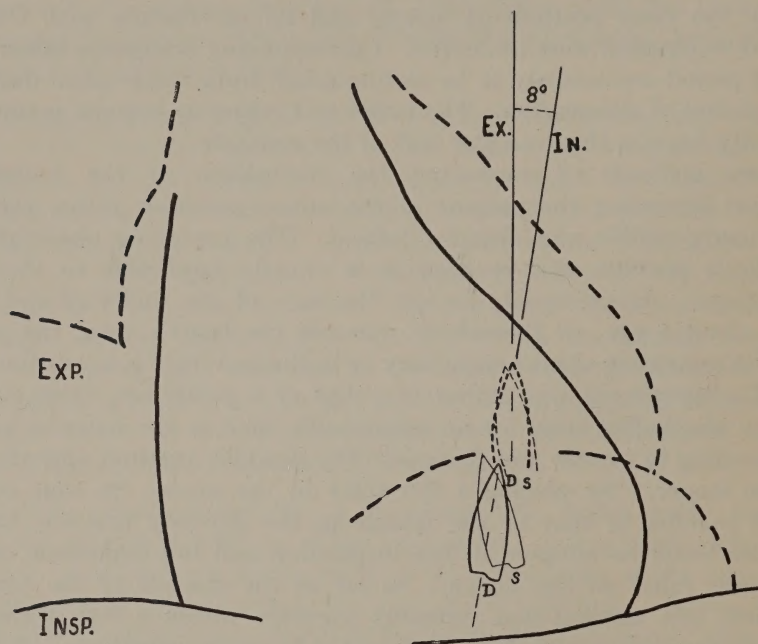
Outlines of the heart and bullet (half natural size) in full inspiration and full expiration, traced from two X-ray plates taken from the patient in the erect posture. The X-ray tube was at 1 metre distance from the screen.
